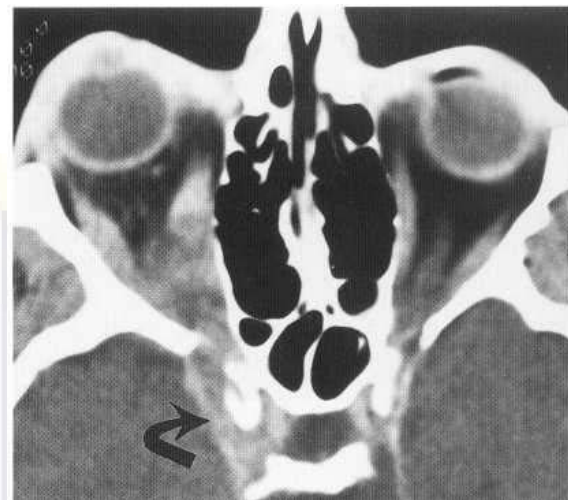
Lymphoma. Enhanced axial CT image demonstrates extension of right orbital apex mass to the right cavernous sinus (arrow) via the superior orbital fissure. There is right proptosis. Enlargement and abnormal enhancement of right medial and lateral rectus muscles could represent infiltration by tumour, but are more likely due to venous congestion from cavernous sinus obstruction. (Case courtesy of Orlando Ortiz, M.D.)
